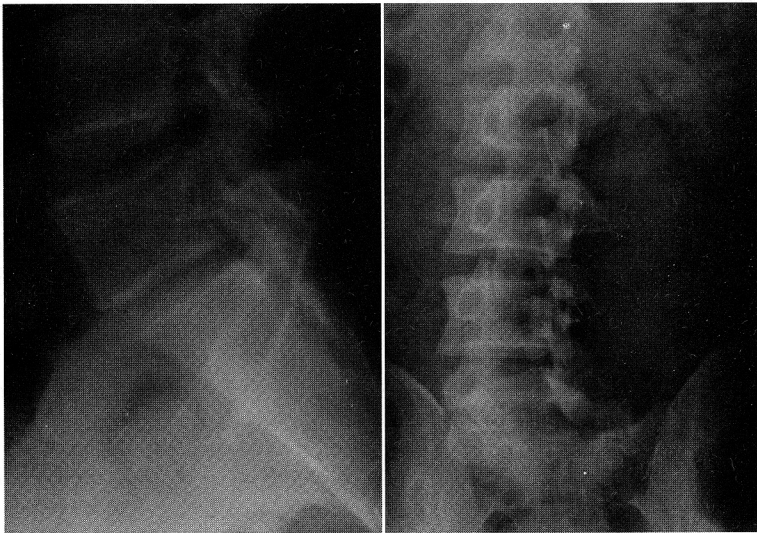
The plain roentgenograms of the lumbosacral spine show right lateral dislocation and the rotational deformity of lumbosacral articulation and a 10% olisthesis of L5 on the sacrum (distance of anterior displacement /anteroposterior diameter of L5 X 100). Also present are transverse process fractures of L4-L5 on the left.
